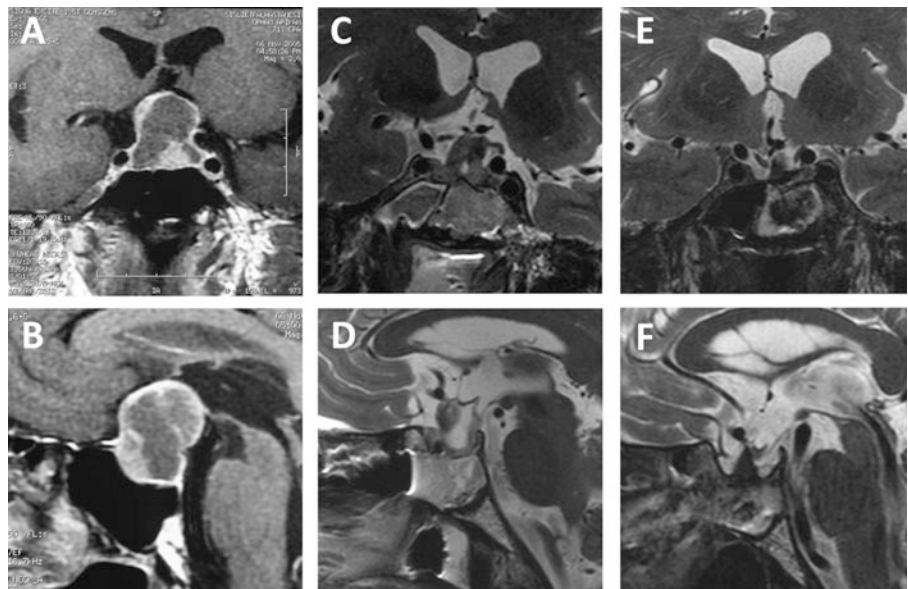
Pituitary macroadenoma with suprasellar extension (as can be seen on coronal (a) and sagittal (b) contrast enhanced images) was operated using 3 T-ultra high field intraoperative MRI. Intraoperatively acquired coronal (c) and sagittal (d) high resolution T2 weighted images revealed total resection. Identical coronal (e) and sagittal (f) T2 weighted images performed at the third month follow-up study confirmed the findings from intraoperative images
